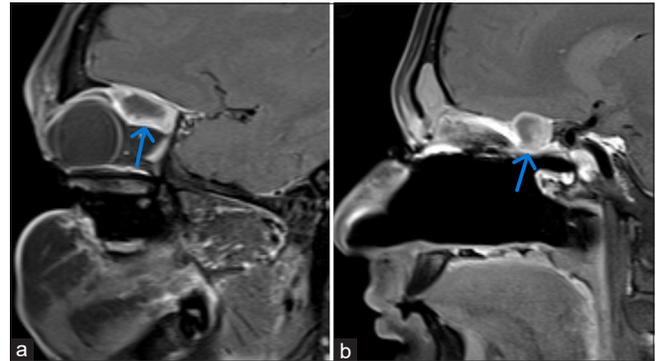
(a-b) Post-contrast T1-weighted sagittal image showing heterogeneously enhancing mass lesion, the blue arrow shows invasion of (a) intraorbital extraconal compartment of right orbit and (b) right posterior ethmoidal air cells.
